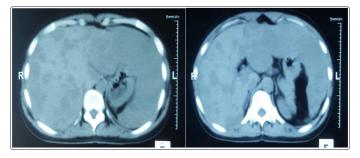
Axial unenhanced CT images of upper abdomen
